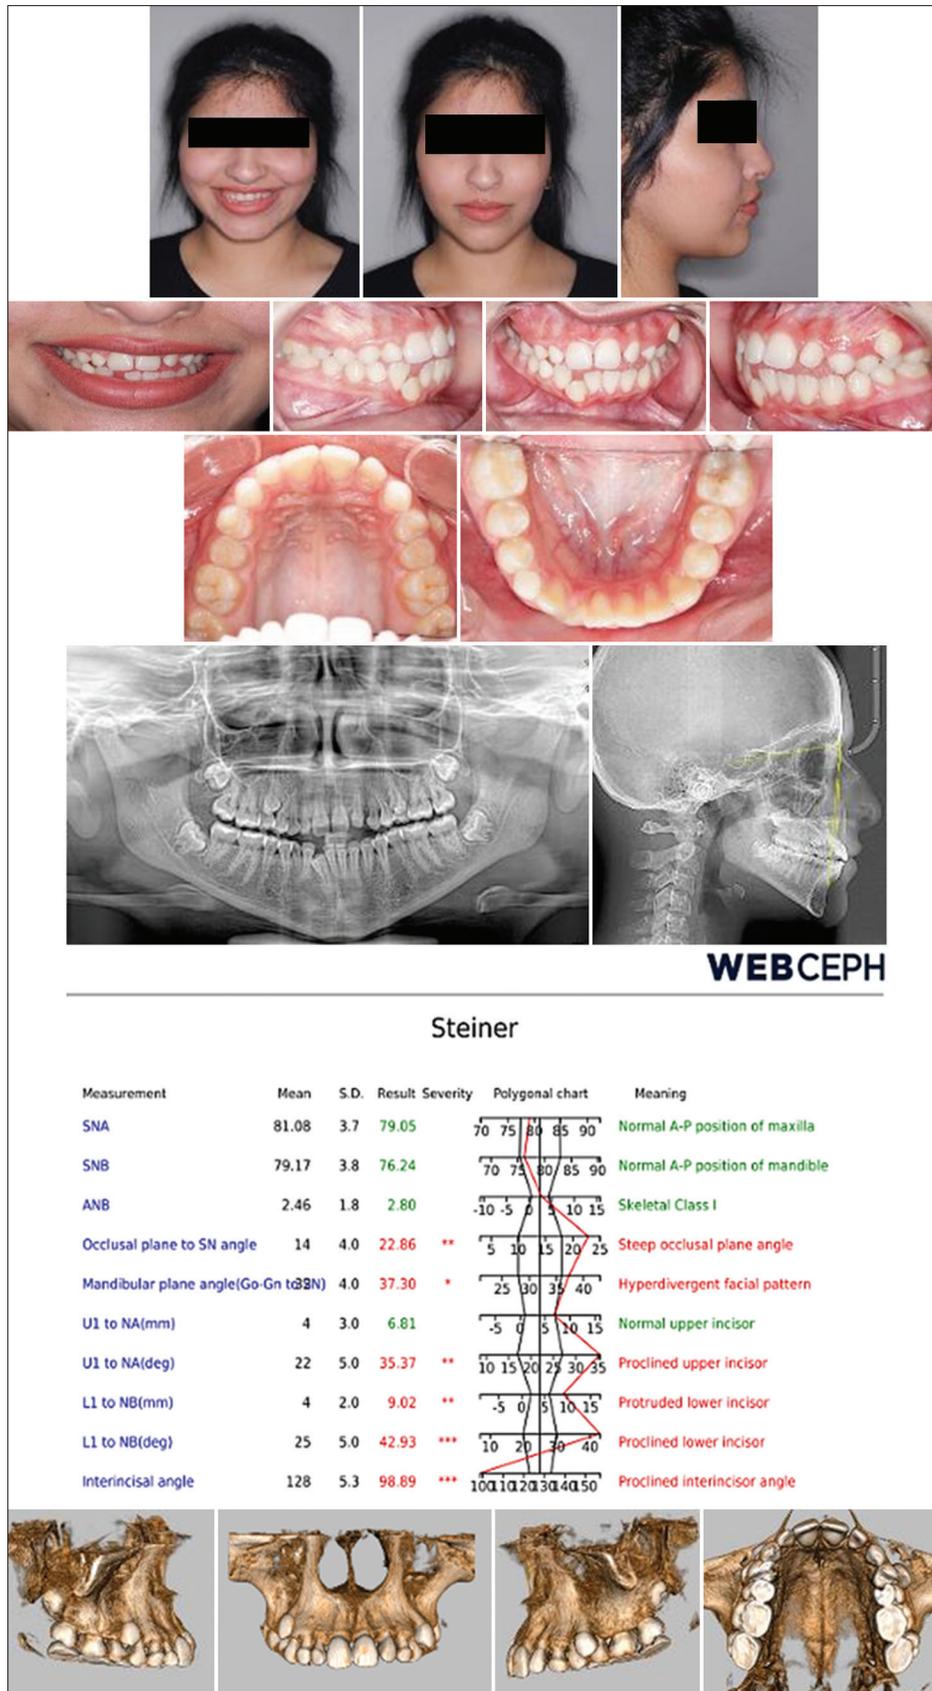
Initial clinical aspect of the patient including (pretreatment extra and intraoral pictures with panoramic X-ray and lateral cephalometric X-ray with tracing confirmed by cone-beam computed tomography)
